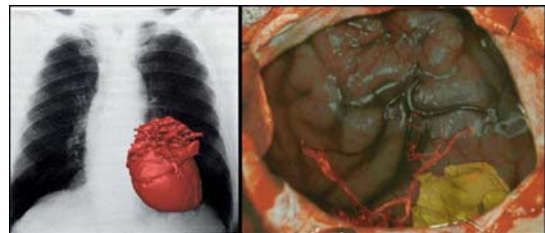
Enhanced reality combines computed anatomic surface models with real-time image data streams (x-ray, video) to enhance visualization and guide interventional procedures.
